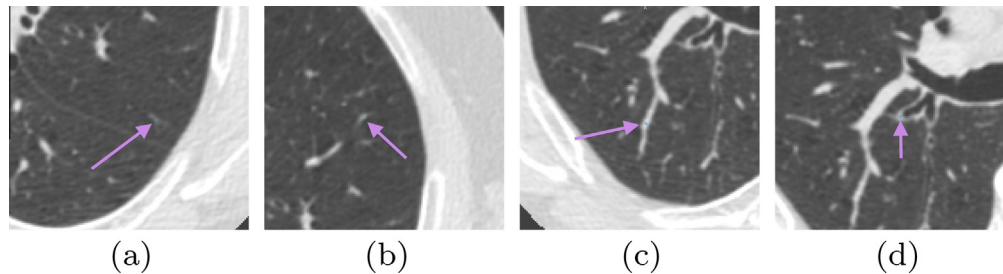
A slice from scan 05 showing (a) small (-818 HU), (b) medium (-727 HU) and (c) large (-382 HU) vessel points. The post-blurring CT values of each vessel point is within the range of CT values corresponding to each vessel size classification. (d) Point showing airway wall.
